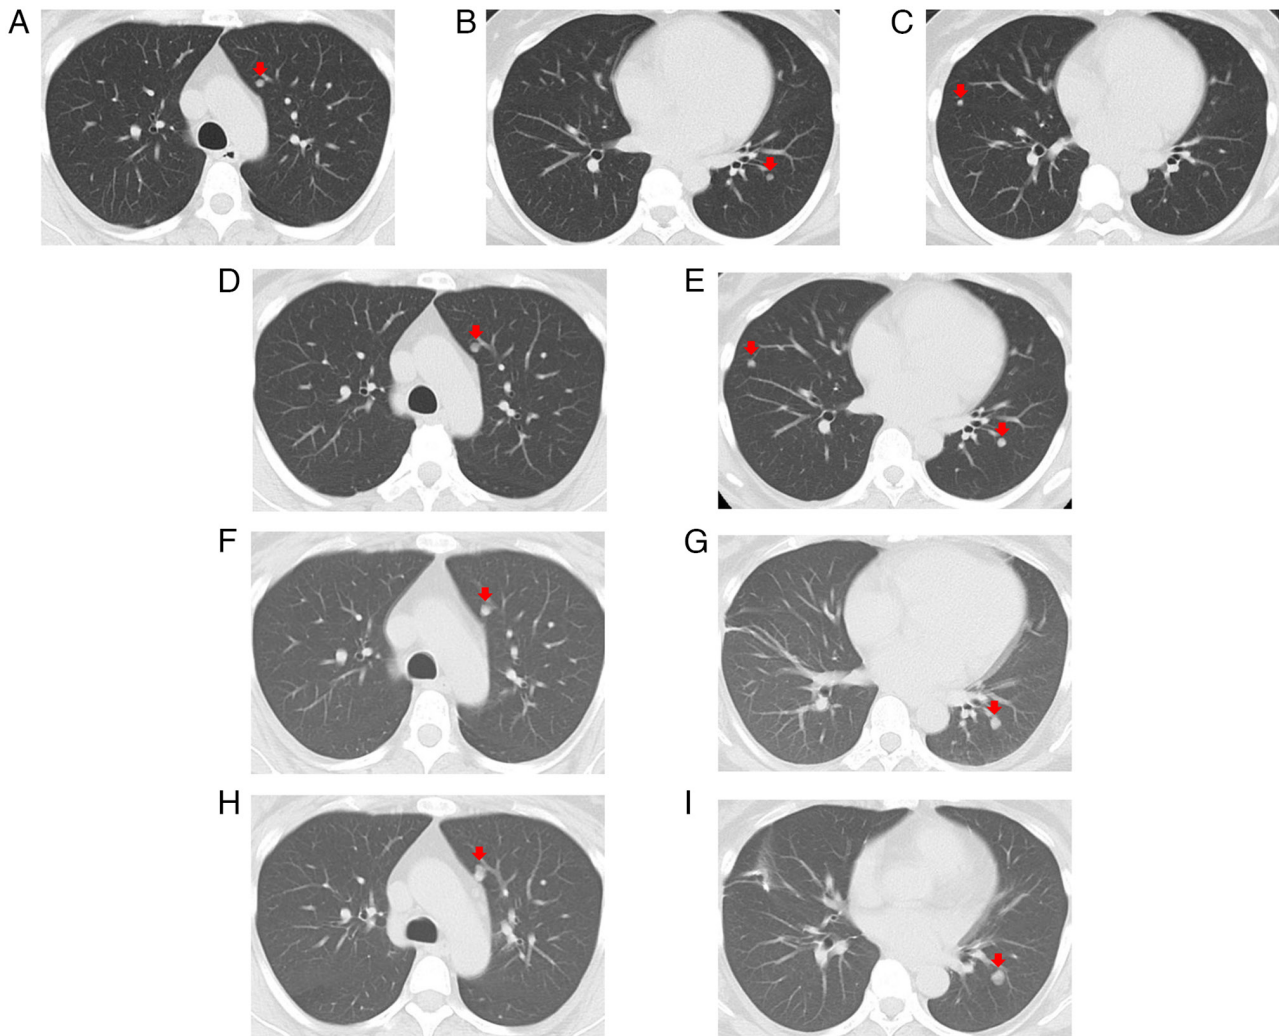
(A) Non-contrast chest CT scan obtained in March 2024 showing a small nodule in the left upper lobe. (B) Non-contrast chest CT scan obtained in March 2024 showing a small nodule in the left lower lobe. (C) Non-contrast chest CT scan obtained in March 2024 showing a small nodule in the right middle lobe. (D) Non-contrast chest CT scan obtained in June 2024 showing enlargement of the left upper lobe nodule. (E) Non-contrast chest CT scan obtained in June 2024 showing enlargement of the nodules in the right middle and left lower lobes. (F) Non-contrast chest CT scan obtained in December 2024 showing further enlargement of the left upper lobe nodule. (G) Non-contrast chest CT scan obtained in December 2024 showing further enlargement of the left lower lobe nodule. (H) Non-contrast chest CT scan obtained in April 2025 showing further enlargement of the left upper lobe nodule. (I) Non-contrast chest CT scan obtained in April 2025 showing further enlargement of the left lower lobe nodule. Overall, the nodules gradually increased in size over time. Red arrows indicate the tumor lesions.
